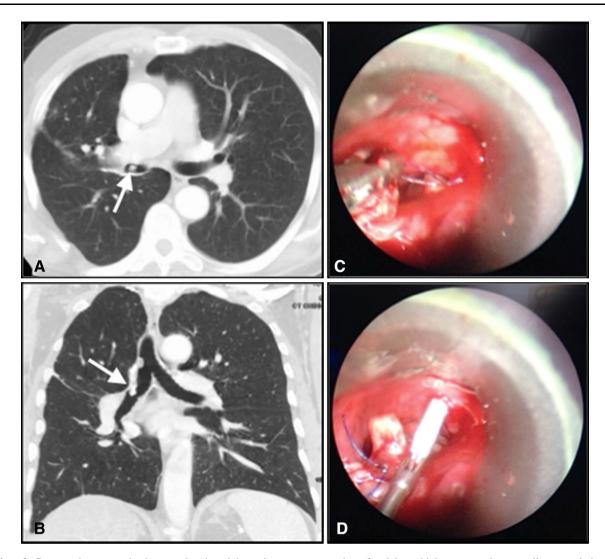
a, b Computed tomography images showing right mainstem partial obstruction at the anastomosis site of right upper lobe sleeve resection (*arrows*). c, d Rigid bronchoscopy images showing
